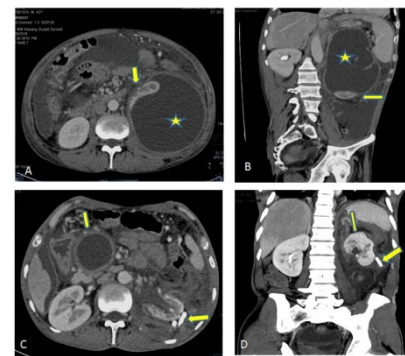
Axial (A and C), oblique MPR (Multiplanar reconstruction B) and coronal MPR (D) images of Contrast Enhanced Computed Tomography (CECT) of abdomen through portovenous phase displaying a large perinephric pseudocyst (stars in A and B) causing gross compression and displacement of left kidney anteriorly (arrow in A) and inferiorly (arrow in 'B') with lesser enhancement as compared to right side, Figures C and D acquired after 18 days of post percutaneous drainage showing pigtail catheter in perinephric space (arrows in C and D), Note near complete resolution of perinephric collection with normal enhancing renal parenchyma (arrow head in D), Note presence of another pseudocyst in relation to the head of the pancreas (arrow head in C).
